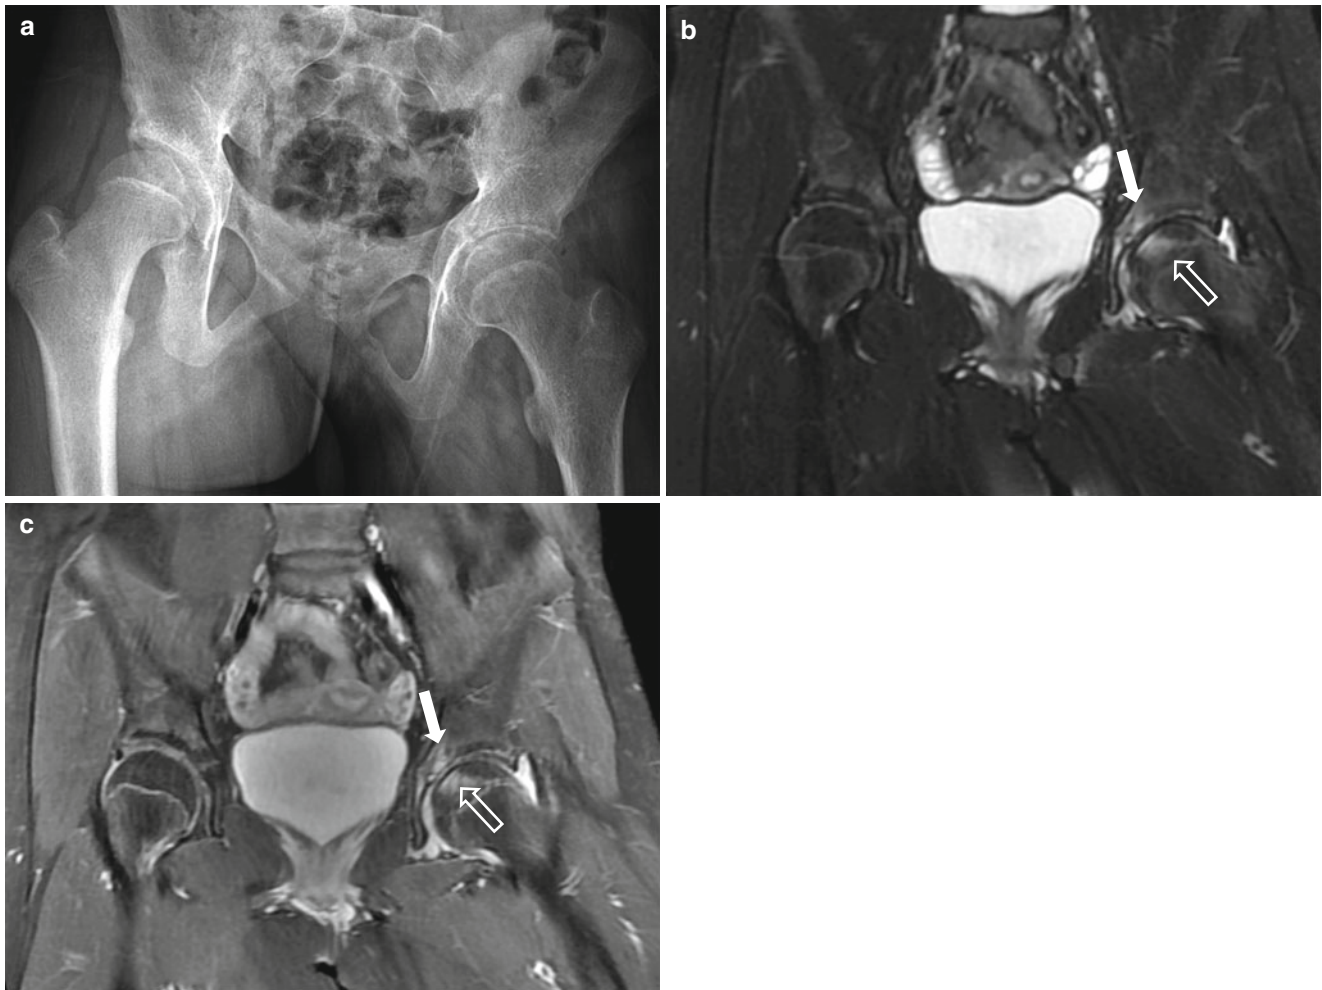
Idiopathic chondrolysis. (a) A 14-year-old girl with left hip joint pain. Anteroposterior radiograph demonstrates diffuse narrowing of the left hip joint with suspected marginal sclerosis in the left acetabulum. (b, c) Coronal T2-weighted image and contrast-enhanced
